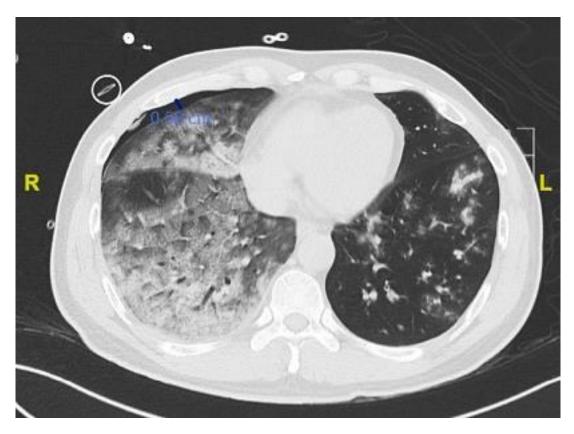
Chest CT scan showing bilateral ranges of pulmonary edema predominating on the right side
